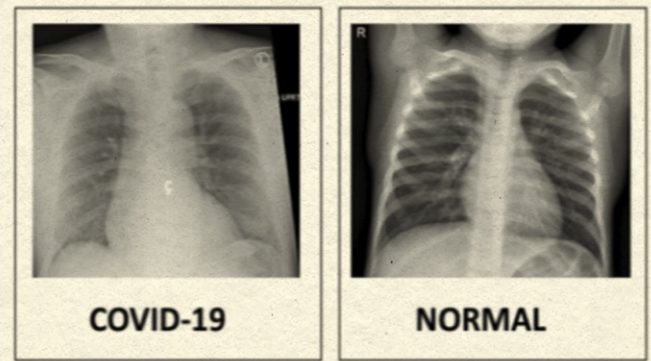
X-ray images of COVID-19 patients vs normal
